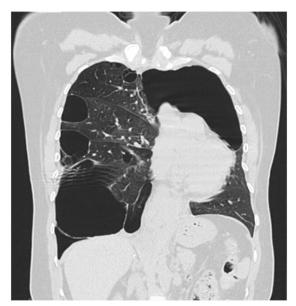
Transversal section of thorax computed tomography. There are two hypodense structures in right lung (anterior and posterior) with atelectasis zones, with peripheral distribution. April 2021
